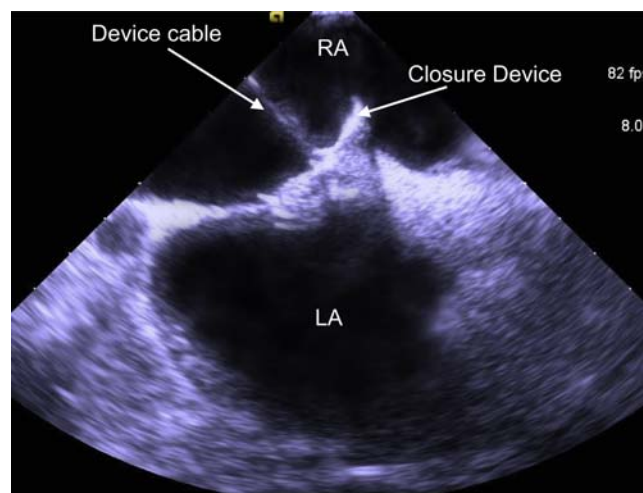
Intracardiac echocardiography (ICE) image showing the closure device “sandwiching” the septum primum on the left and septum secundum on the right. The ICE image is shown from the point of view of the probe in the right atrium (RA), but it is rotated 90 degrees from the true anatomic position so that the septum primum points in the inferior plane and the septum secundum is superior. There is tension from the delivery cable causing the device to tilt into the RA and toward the inferior vena cava. LA, left atrium.
